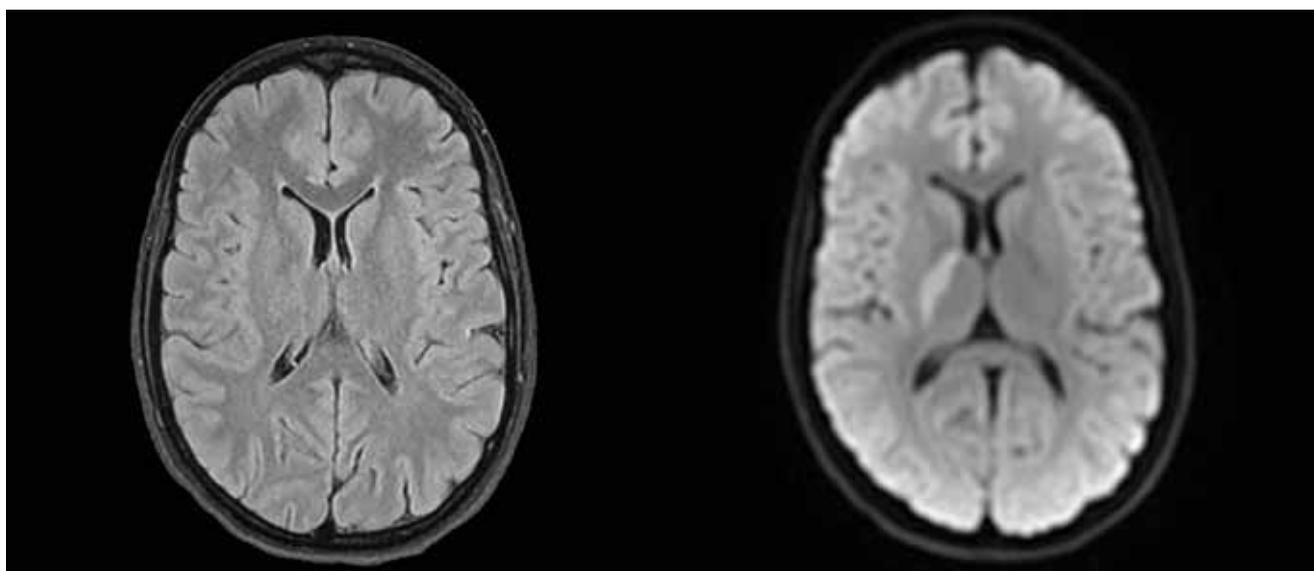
a. Axial FLAIR weighted brain MRI image displaying the absence of cerebral lesions;
